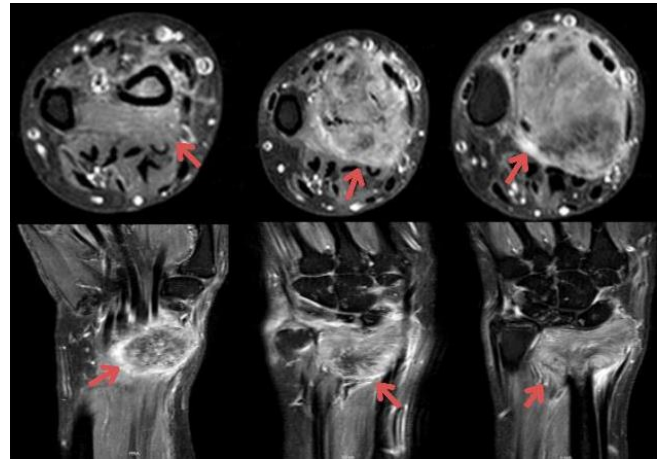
Magnetic resonance imaging (MRI) of the left wrist showing tumour replacement of the distal radial metaphysis
